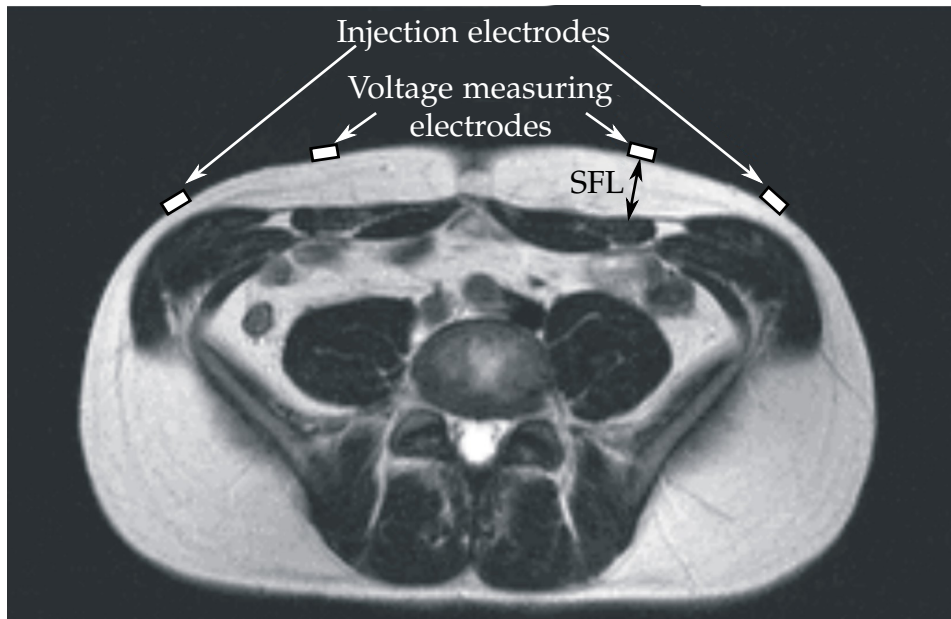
Magnetic resonance image showing the positions of current injection and voltage measuring electrodes as well as the definition of the subcutaneous fat layer thickness (SFL). Modified from Scharfetter et al., 2005.
